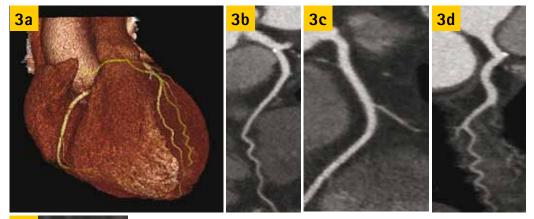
Computed tomography coronary angiography images from a 60-year-old female patient with chest pain. Patient and scan parameters were: BMI 24, heart rate 63 after 25 mg intravenous metoprolol, 50 ml lomeron 400 contrast, tube voltage 100 kV, tube current 440 mA, scan range 140 mm, half-scan reconstruction and phase window 70-80%. I mages were reconstructed using AIDR. The total dose length product was 137.7 (1.9 mSv using a k-factor of 0.014). A: Three-dimensional reconstruction of the heart. Curved planar reconstructions of B: left anterior descending artery, C: right coronary artery and D: left circumflex artery.
